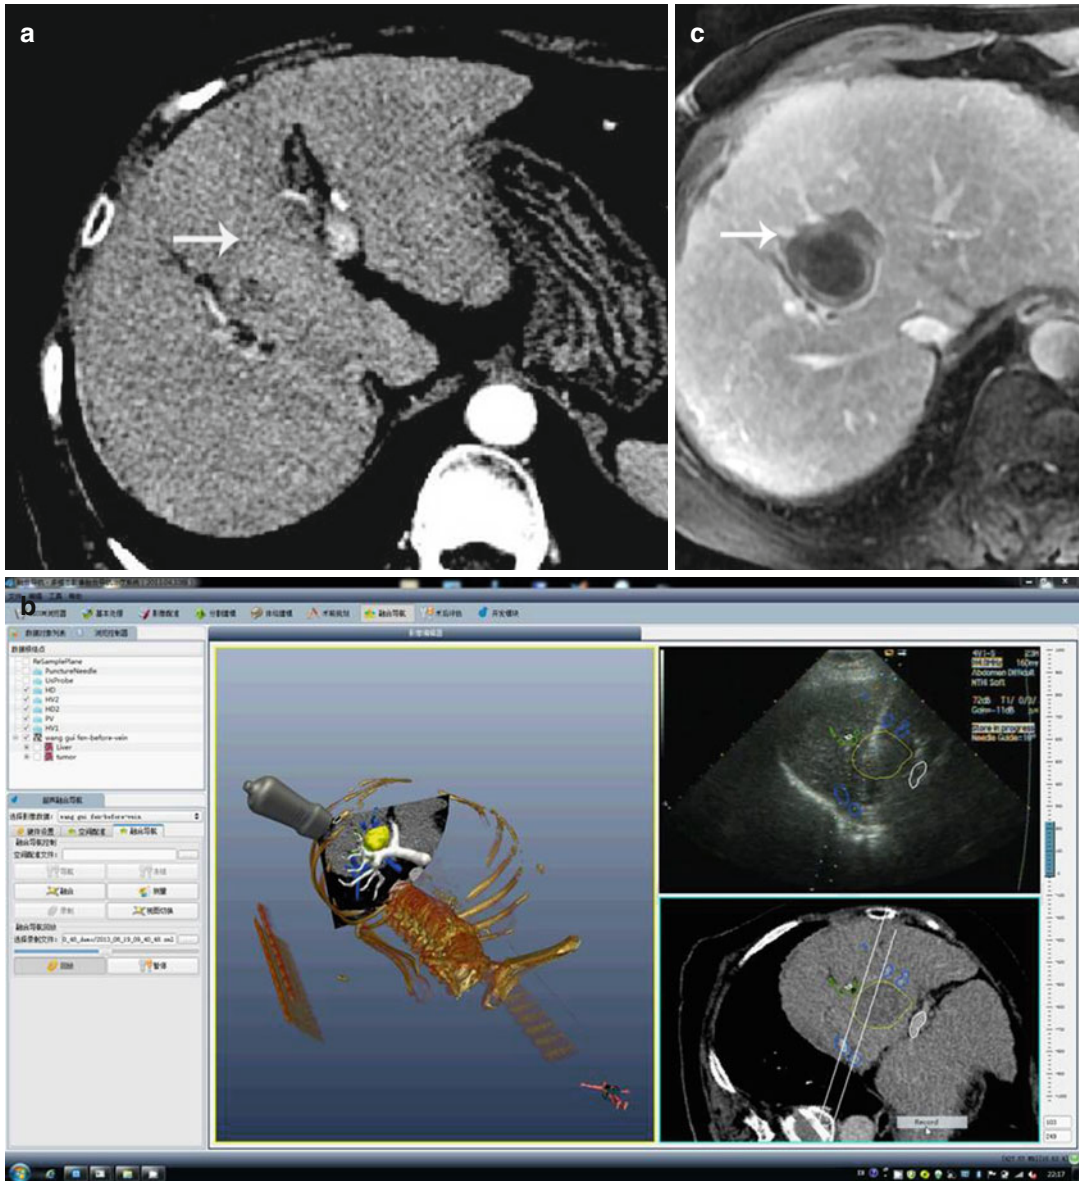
Images in a 75-year-old patient with a tumor in the liver segment VIII. (a) Preoperative CT image showed that the tumor (*white arrow*) was close to portal vein. (b) The patient was performed MWA assisted with 3D
